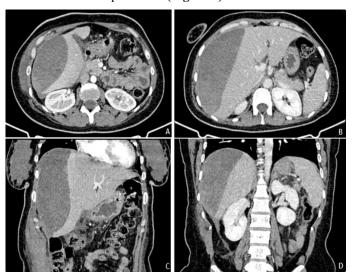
post-operative CT scan showing a subcapsular hematoma surrounding the lateral surface of the right hemi liver, with no active bleeding or ruptured capsule
